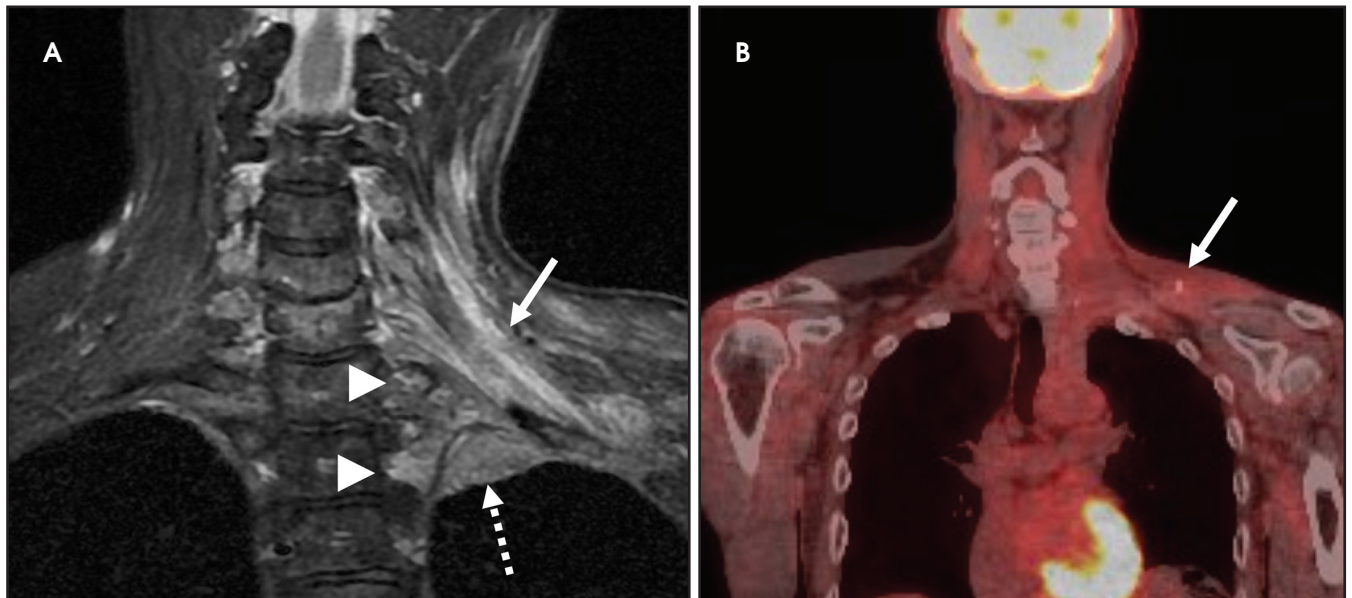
Post-radiation brachial plexopathy in a 53-year-old with metastatic hypopharyngeal squamous cell carcinoma. Coronal, T2W, fat-saturated MRI sequence (A) and a coronal reconstruction from a subsequent FDG-PET/CT (B). There is extensive T2W hyperintense aggregation and thickening of the left brachial plexus (solid arrow in A), involving the roots through to the cords with overlying soft tissue and muscular thickening and edema. There is nodular soft tissue at the left lung apex (dashed arrow) with altered signal at the left first and second ribs (arrowheads in A). Compared to the pre-radiation studies (not shown) the edema and neural thickening showed interval increase in extent with no new focal mass. Along with the paucity of FDG avidity at the left brachial plexus (solid arrow in B) and thoracic inlet on the PET/CT, these findings were compatible with post-radiation plexopathy, left apical fibrosis and post-radiation osteonecrosis of the ribs. Continued surveillance was recommended as this patient remained at high risk of recurrence.
